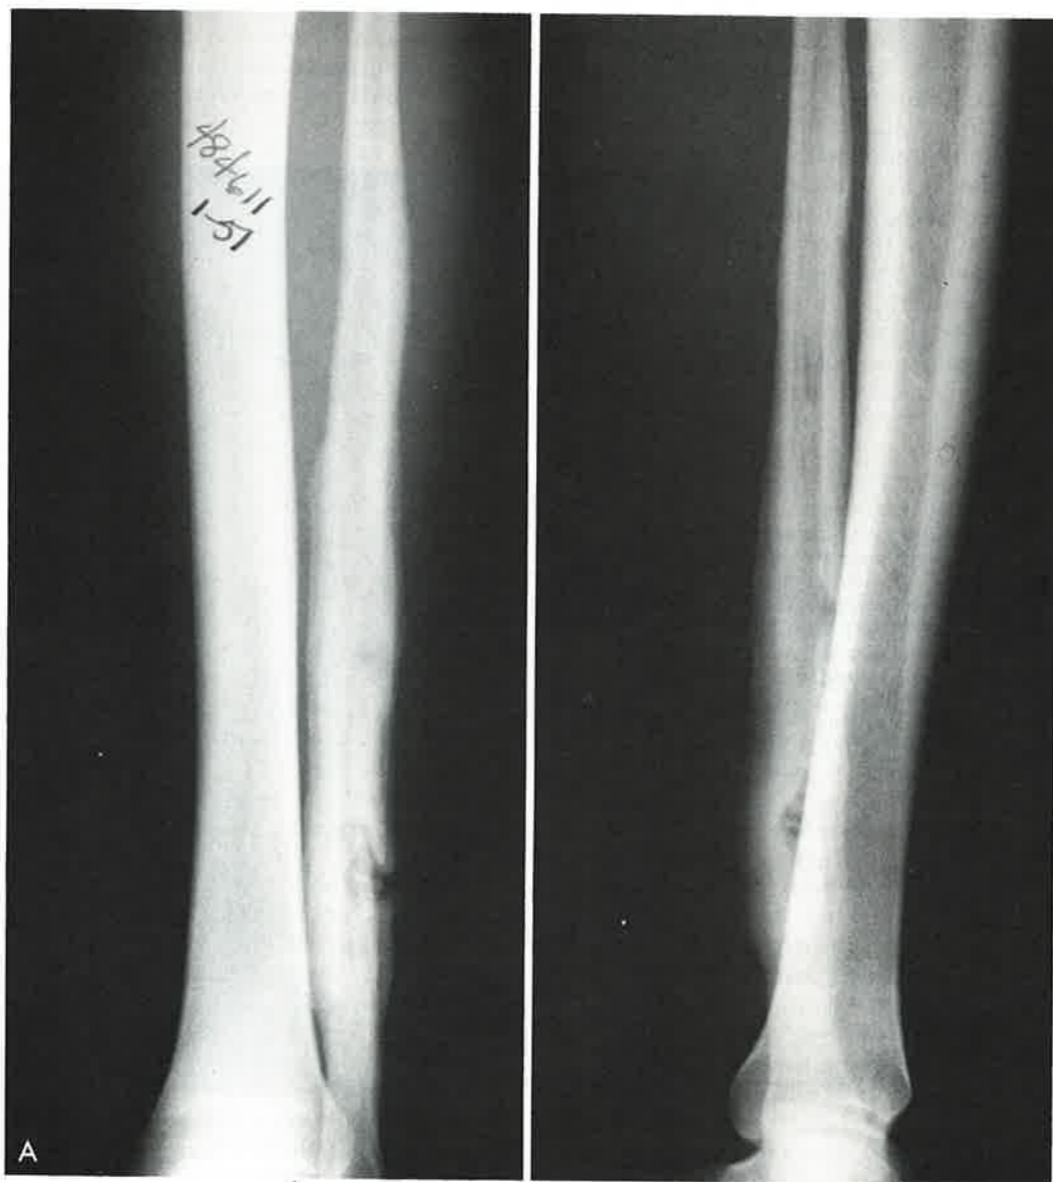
Solid undulating periosteal reaction. Chronic osteomyelitis of the fibula. A, Clinical radiographs reveal the varying thickness of the periosteal reaction pattern and endosteal sclerosis.
